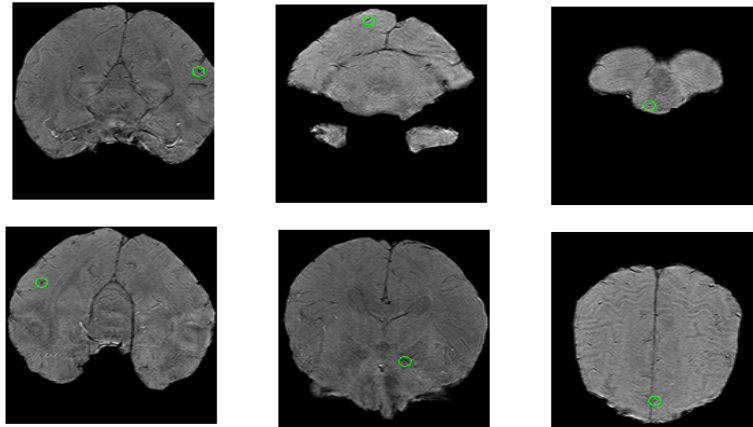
Some results of false-negatives in T2* MRI images. The green circles indicate the location of the FNs.
